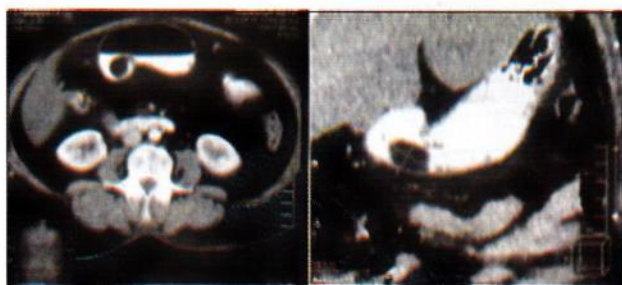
CT scan showing a pedunculated mass arising from lesser curvature of the stomach.
